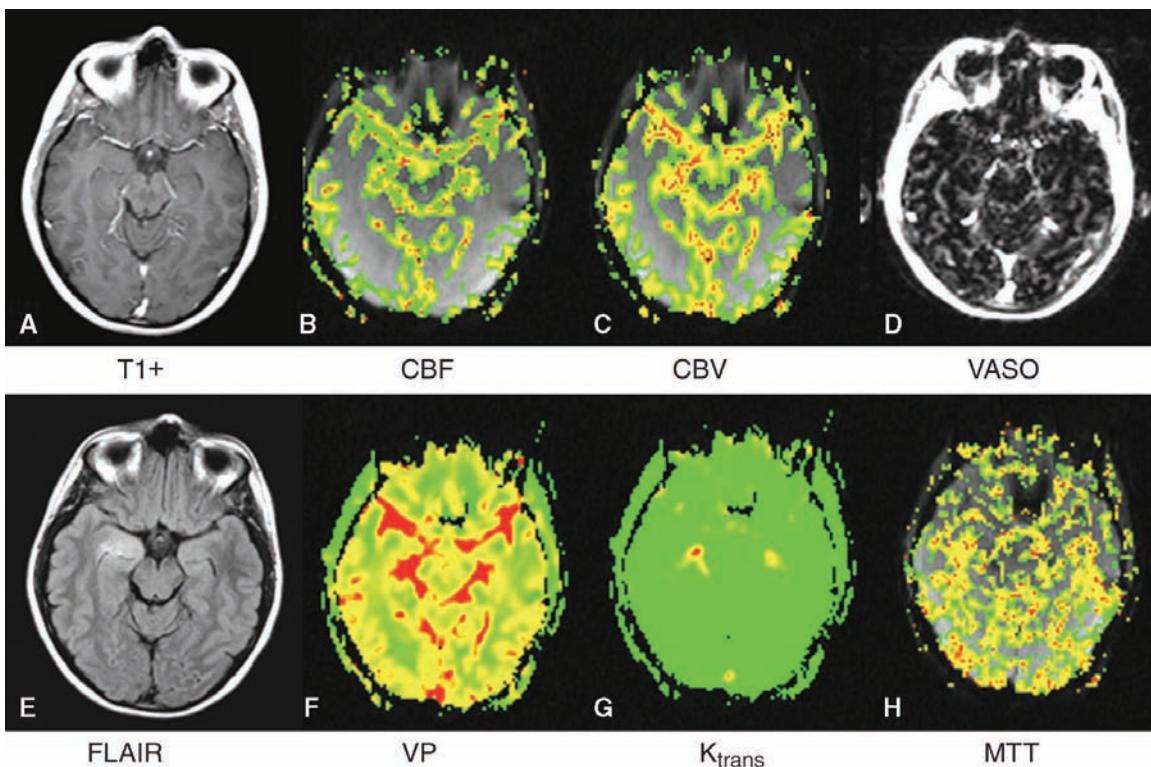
Pathologically proven right mesial temporal low-grade glioma. (A) Axial T1-weighted postgadolinium image. (B/C) Gradient-echo axial DSC MRI, CBF, and CBV overlay images demonstrating a lack of increased perfusion. (D) Vasoperfusion image also confirming that there is no increased perfusion within the low-grade glioma. (E) Axial FLAIR image demonstrating increased signal within the right mesial temporal lobe. (F/G/H) Gradient-echo axial DSC MRI with V_p , K^{trans} , and MTT color overlay demonstrates no increase in V_p , K^{trans} , or MTT. Abbreviations: FLAIR, fast fluid-attenuated inversion recovery; DSC MRI, dynamic susceptibility contrast MRI; CBF, cerebral blood flow; CBV, cerebral blood volume; V_p , blood plasma volume; K^{trans} , vascular permeability; MTT, mean transit time. Source: From Ref. 112.
